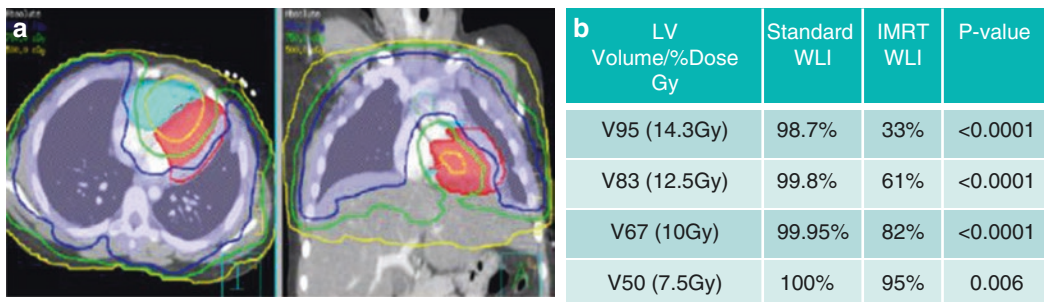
Cardiac sparing 4-dimensional-based intensity modulated radiation therapy (IMRT) plan showing 95% isodose line (blue), 75% (green line), and 50% (yellow line) on CT images of left ventricle (red), right ventricle (light blue), and whole lung planning target volume (purple).
